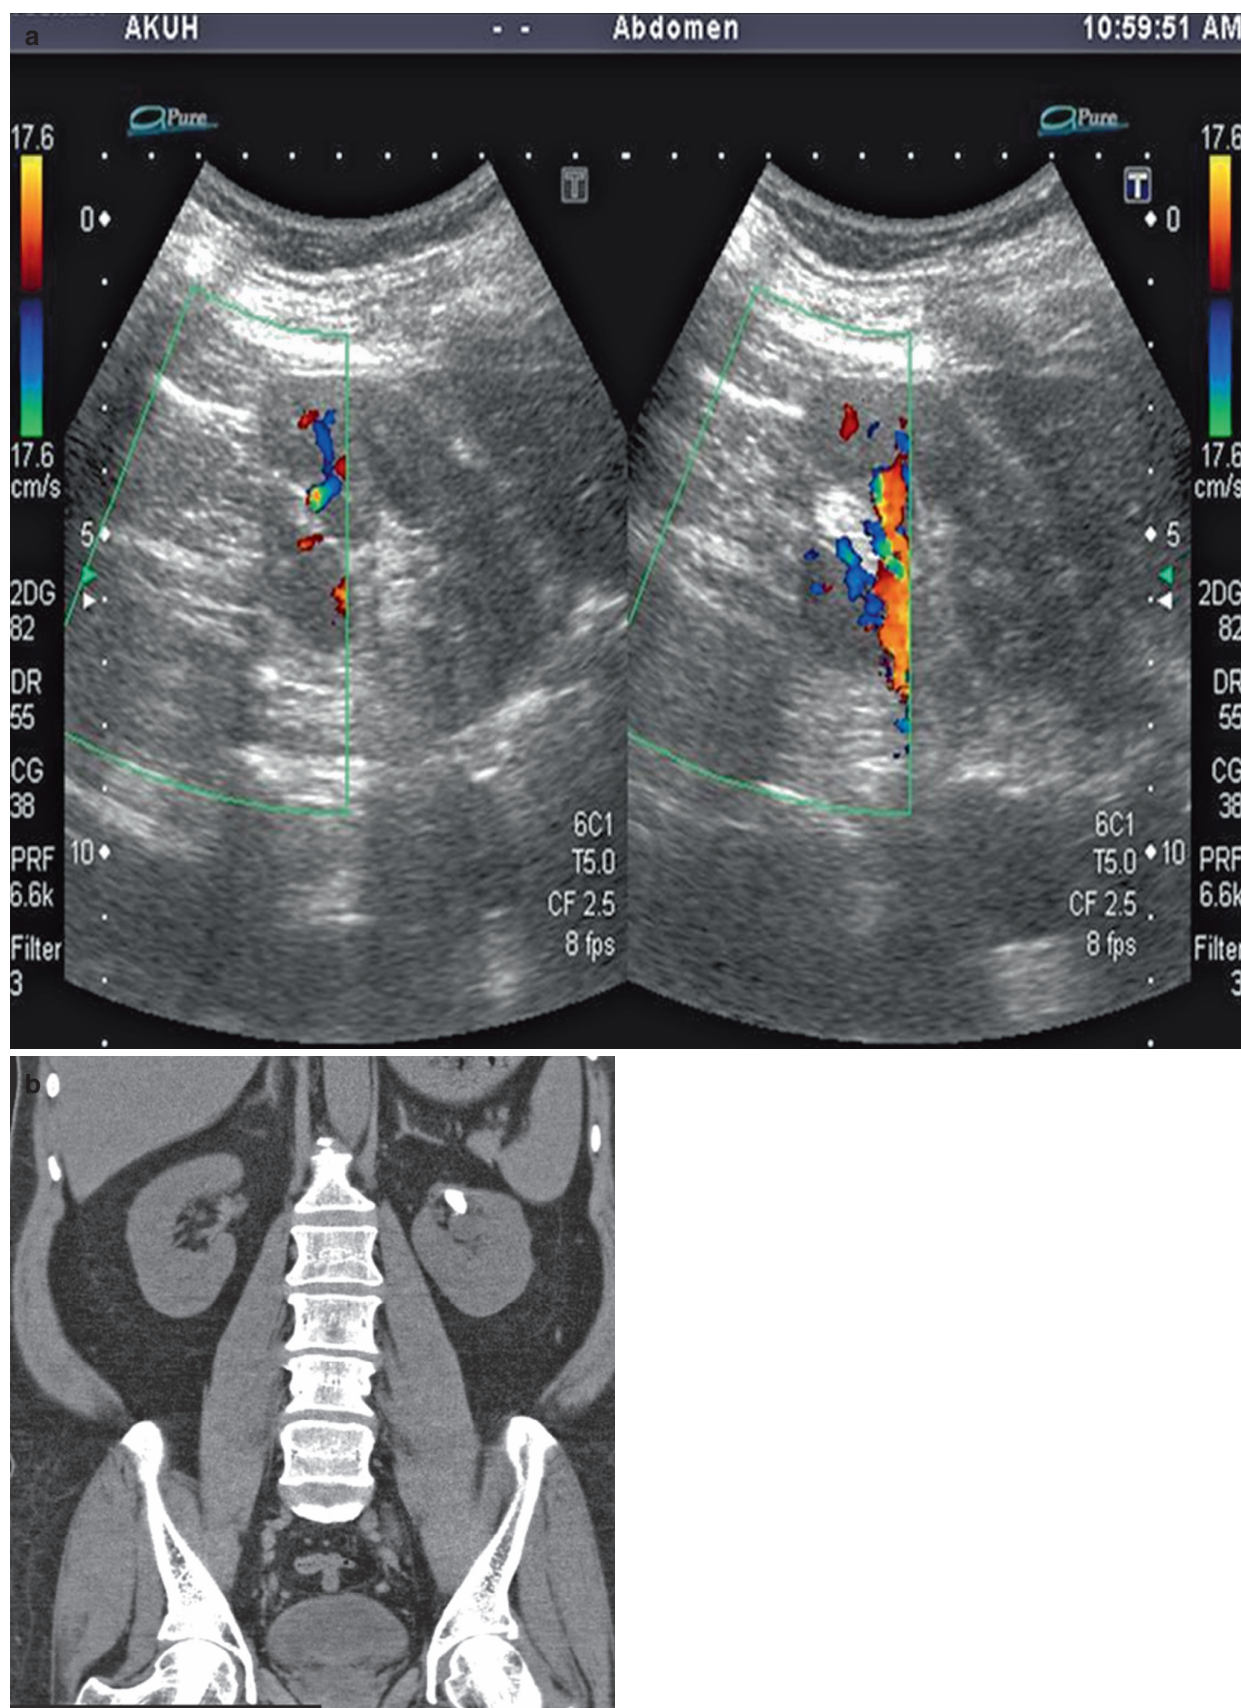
(a) Ultrasound and (b) CT KUB scan showing stones
